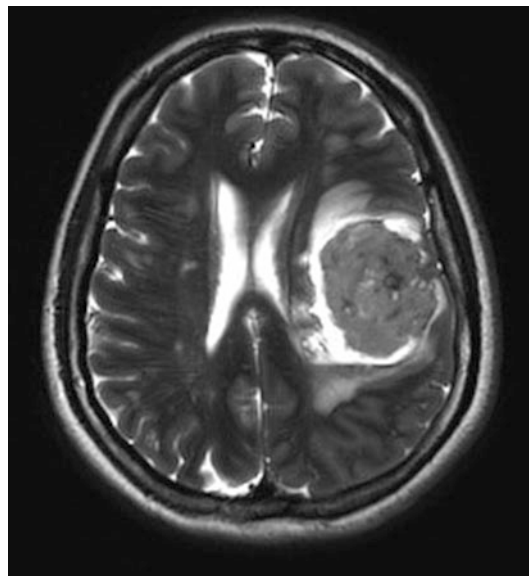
MRI-axial T2-weighted sequence – acute intracerebral haemorrhage
